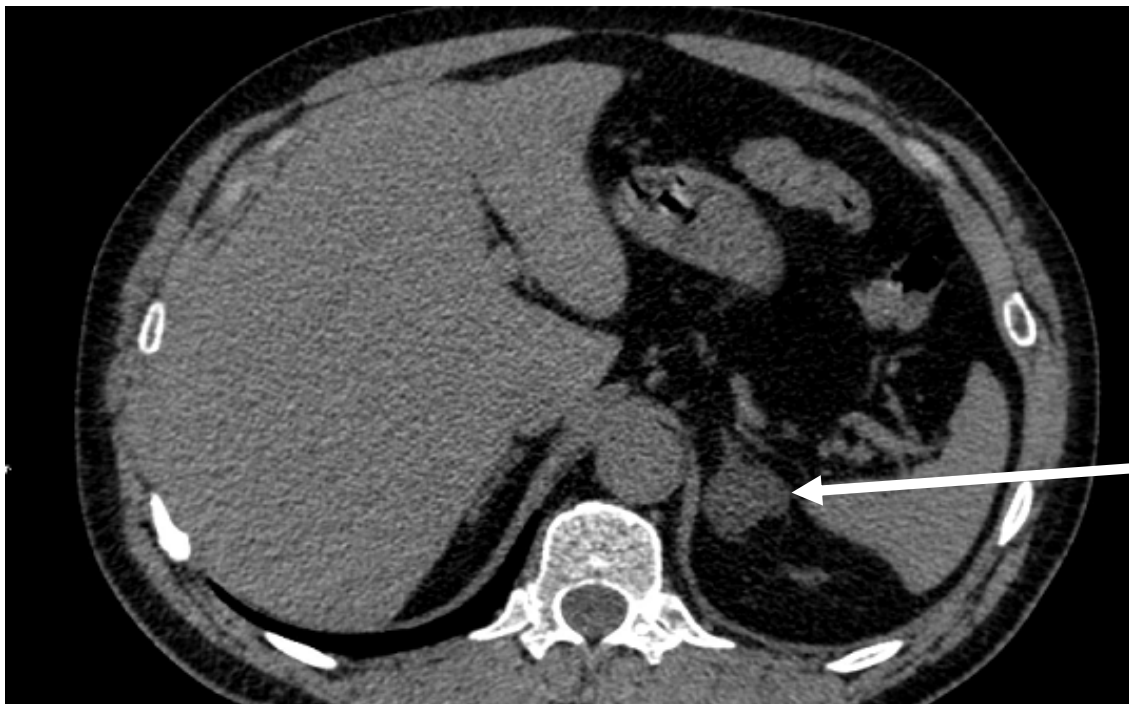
Unenhanced CT of a left adrenal adenoma (arrow)
